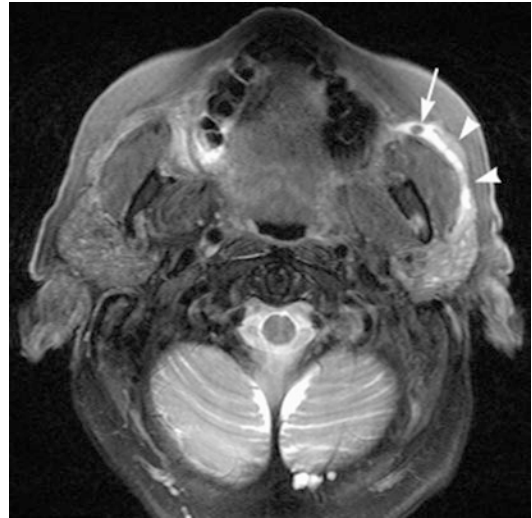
T2-weighted MRI scan allows visualization of salivary stasis within a dilated left parotid duct (*arrowheads*). The distal portion of the duct is obstructed with a salivary stone (*arrow*) that can be seen when surrounded by the hyperintense saliva within the duct
